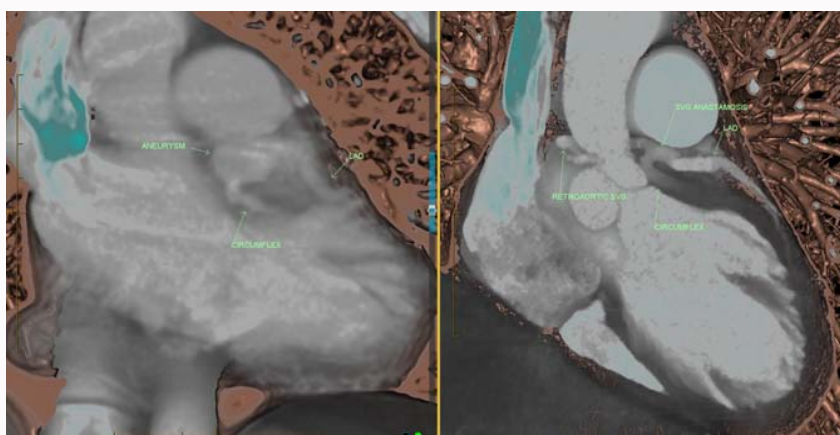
(Left/Right) CTA images before and after. (Left) Preoperative non-gated CT depicting a 3.0 cm fusiform left main aneurysm giving rise to the LAD and circumflex branches. No definitive thrombus or intimal flap per non-gated resolution. (Right) Post left main aneurysm resection with widely patent Saphenous Vein Graft (SVG) anastomosis and preserved flow through the visualized circumflex and LAD branches. Note the retroaortic course of the SVG which was anastomosed to the anterior aorta (not shown).
